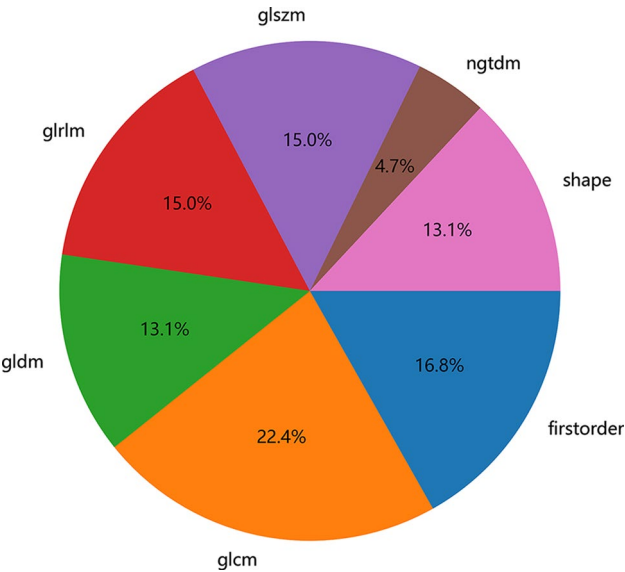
Percentage of handcrafted features extracted based on CT images. GLCM, gray-level co-occur-rence matrix; GLDM, gray level dependence matrix; GLRLM, gray-level run length matrix; GLSZM, gray-level size zone matrix; NGTDM, neighborhood gray-tone difference matrix
